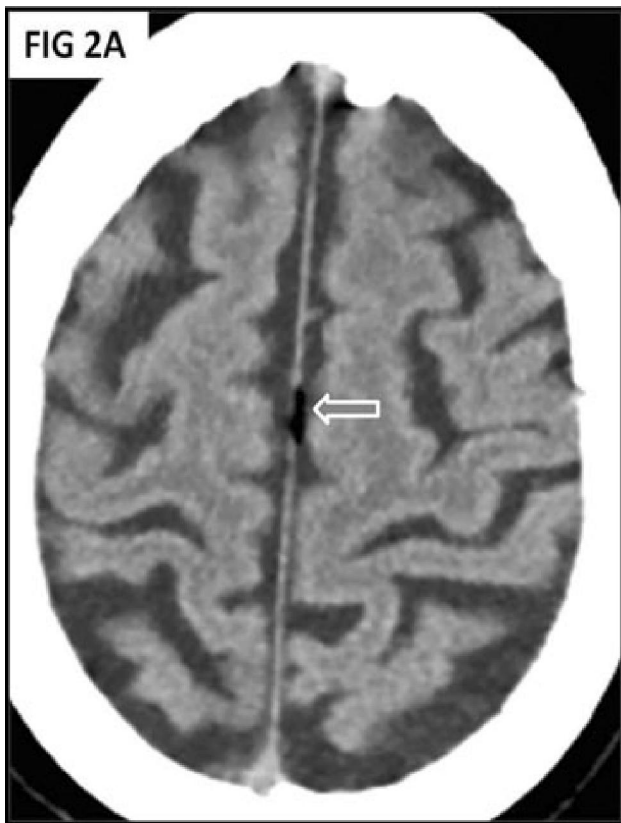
and 2B: NECT brain showing hypo dense fatty falx in midline having a CT density of -22 H.U.
